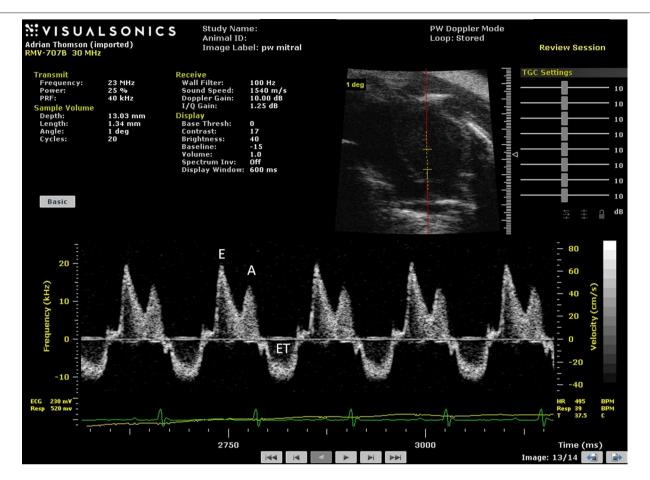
Spectral Doppler trace with Doppler sample volume situated in center of left ventricle enables both inflow and outflow from the left ventricle to be measured with early (E) and late (atrial—A) waves and ejection time (ET) highlighted in the spectral Doppler trace. In addition isovolumic relaxation time (IVRT) and isovolumic contraction time (IVCT) may be measured where IVRT is equal to the time from the closure of the aortic valve to opening of mitral value and IVCT is the time of closure of mitral valve to opening of aortic valve.
